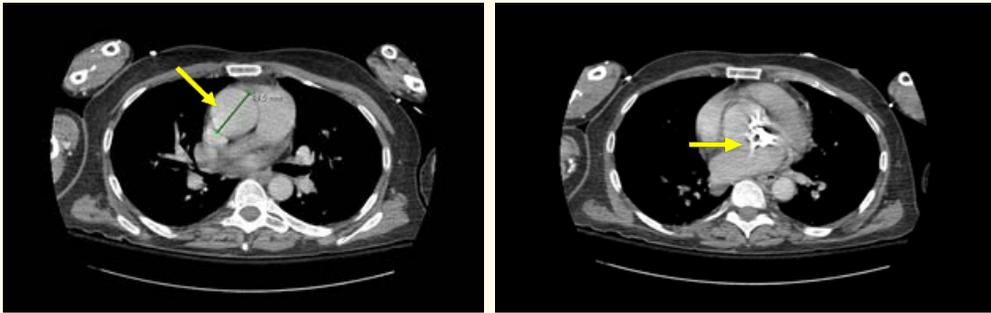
CT thorax with contrast showing an ascending thoracic aortic aneurysm.
